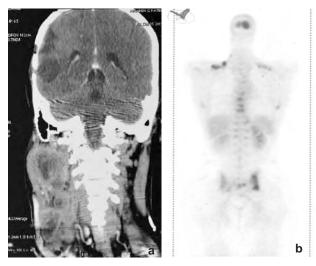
CT brain and neck in December 2011 showing postoperative gliotic change. Multiple enlarged lymph nodes in the right side of neck largest are seen (a). PET CT-hypermetabolic disease involving multiple level cervical nodes and bones (b)
